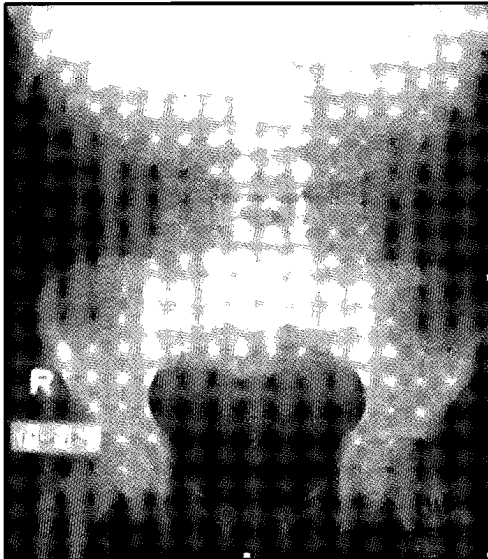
Plain abdominal X-ray of a female 11-year-old child showing a stone in the middle third of the right ureter.
